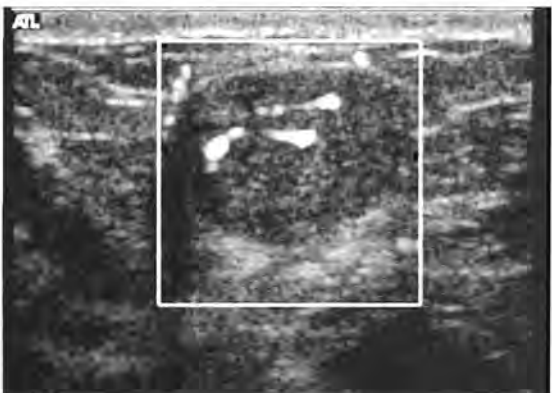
Vascularity. The role of vascularity in the characterization of breast masses is not fully defined. Therefore, description of vascular features is optional. Vascularity assessed with color or power Doppler is described as the same, increased, or decreased compared with adjacent normal breast tissue. Power Doppler of a high-grade carcinoma with increased vascularity (arrowheads) is shown.
